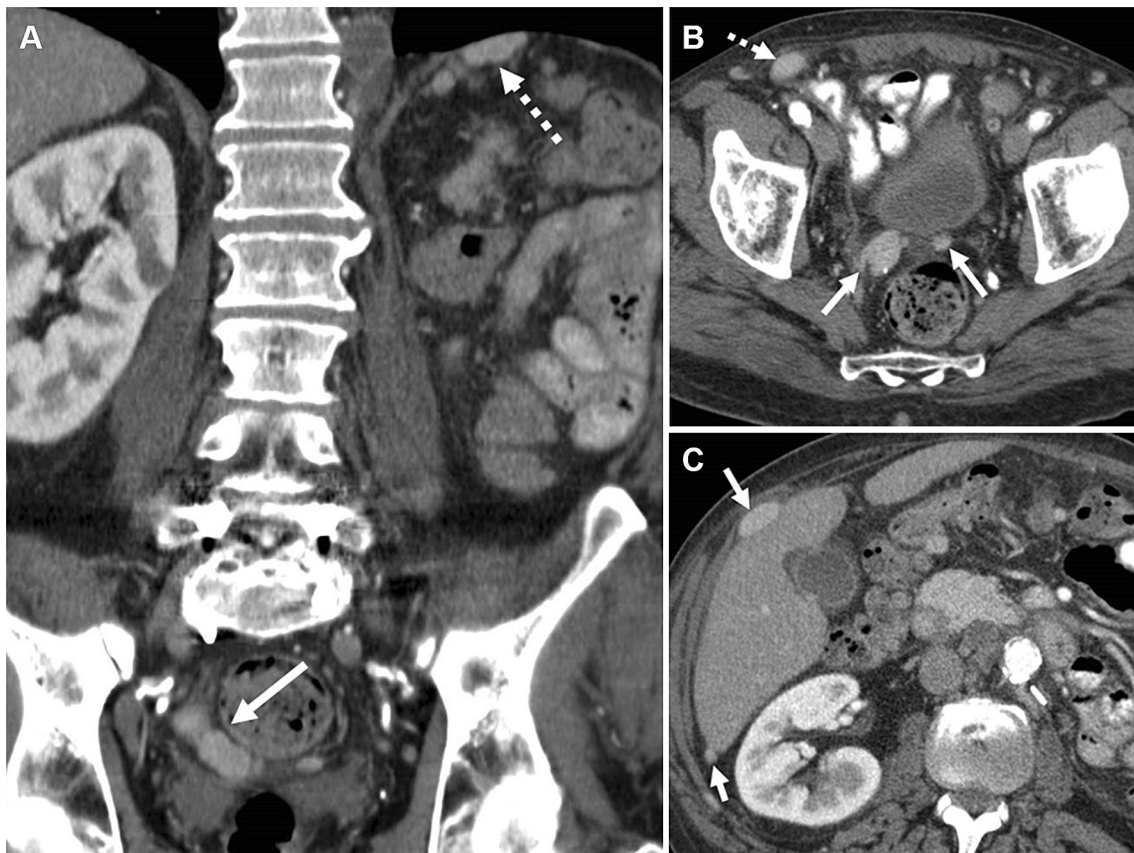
Coronal (A) and axial (B, C) contrast-enhanced CT images demonstrate enhancing soft tissue nodules in the left upper quadrant (dotted arrow, A), in the pelvic peritoneal
